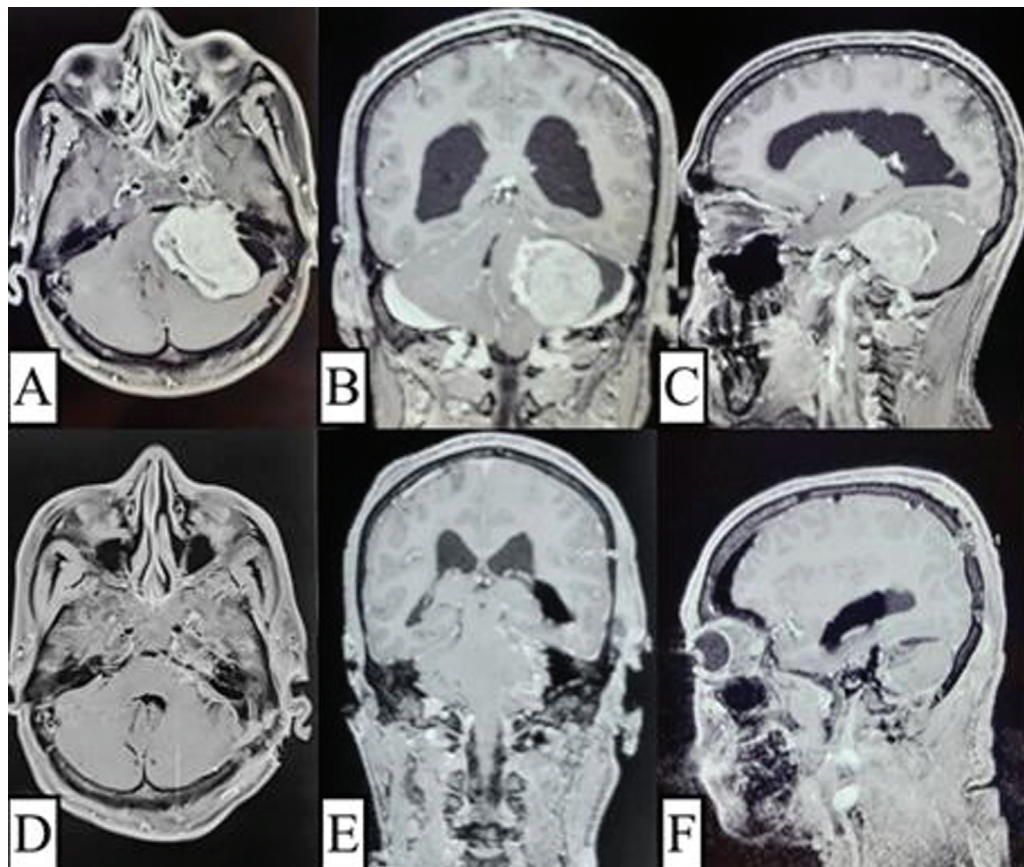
Magnetic resonance imaging preoperative axial, coronal, and sagittal (A–C) showing giant vestibular schwannoma, and postoperative image (D–F) showing complete tumor removal.
